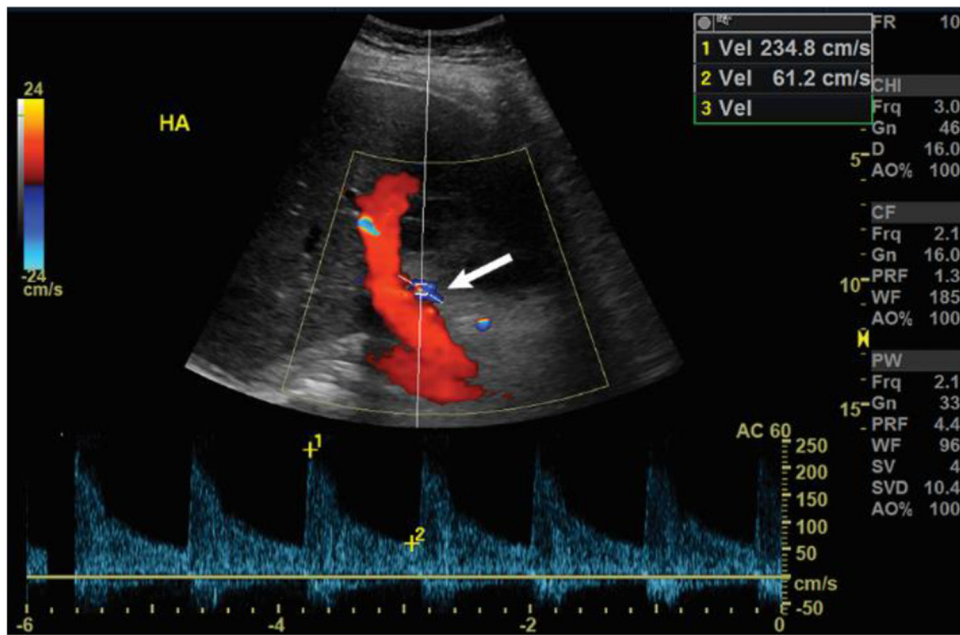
Transabdominal sagittal spectral Doppler ultrasound image at the porta hepatis showing the common hepatic artery being appropriately measured, with angle correction and measured parallel to the portal vein (red vessel). This hepatic velocity artery is elevated at 234.8 cm/second.
